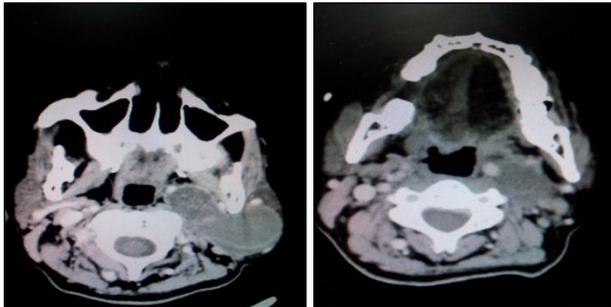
CT (axial cuts) showing tumour splayin the internal jugular vein from internal carotid artery
